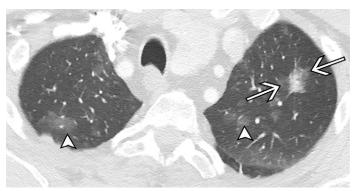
Multiple ground-glass or lepidic lesions (multifocal adenocarcinoma) in a 70-year-old man with NSCLC. Axial contrast-enhanced CT image (lung window) shows that the primary tumor is the leading nodule. The part-solid nodule in the left upper lobe (between arrows) has an overall diameter of 2.2 cm, and the solid component measures 1.2 cm; this would normally be described as a T1b lesion. However, there are numerous additional ground-glass nodules (arrowheads) in both lungs. For multiple ground-glass lesions or lepidic tumors, the IASLC advises using the dominant lesion for T staging. Because of the multiple additional ground-glass nodules, the overall descriptor is T1b(m), (with "m" for multiple). In counting the additional foci of ground-glass malignancy, only nodules larger than 5 mm are included because those with a diameter up to 5 mm are thought to represent atypical adenomatous hyperplasia, a precursor to lung adenocarcinoma.
